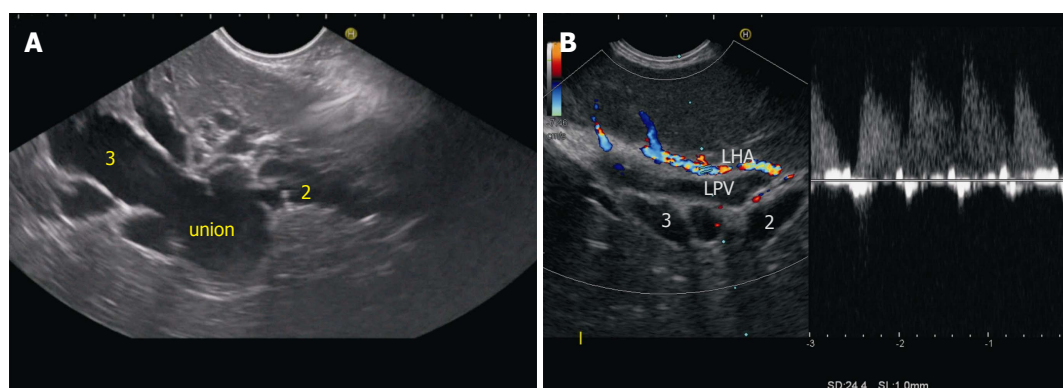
Union of segmental ducts. A: Segment 2 is identified as duct coming from cranial part of liver segment and segment 3 duct is identified as duct coming from caudal part of liver segment; B: Sometimes the ducts are not dilated and in such situation the tributaries of left portal vein can be identified after application of color doppler and followed to the union and formation of umbilical part of portal vein. LPV: Left portal vein; LHA: Left hepatic artery.
